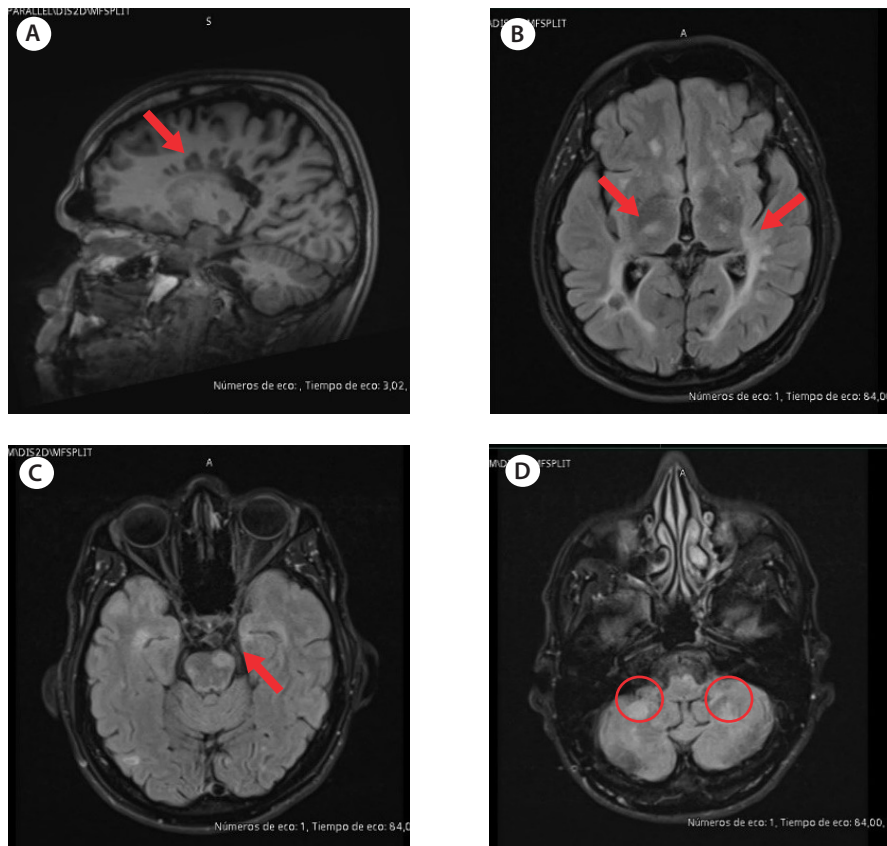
Brain magnetic resonance imaging using Avanto 1.5 Tesla equipment, T1-weighted and FLAIR sequences. (A) Sagittal T1-weighted section showing hypointense lesions at the margin of the corpus callosum (callosal-septal interface) and some with a perpendicular arrangement to the ventricular system. (B) Axial slice, FLAIR sequence, showing hyperintense cortical, juxtacortical, subcortical (bilateral thalamus), and confluent periventricular lesions in contact with the ependymal surface. (C) Axial section, FLAIR sequence, bilateral parieto-occipital cortical hyperintense lesions, bilateral hippocampal juxtacortical lesions, and infratentorial lesions in the pons. (D) Axial section, FLAIR sequence, hyperintense lesions in both cerebellar hemispheres. None of the lesions showed post-contrast enhancement or diffusion restriction.
